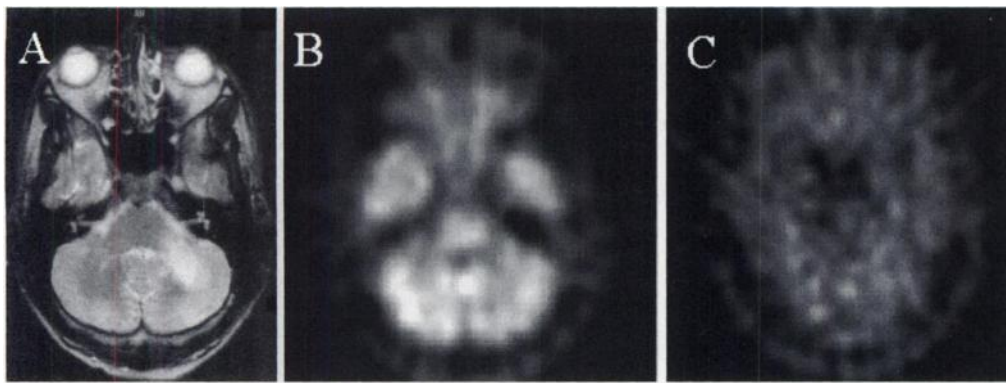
MR appearances in a patient with progressive multifocal leukoencephalopathy showing abnormal signal in the left cerebellum (A), demonstrating the low-grade uptake of FDG (B) and MET (C) within the lesion.
